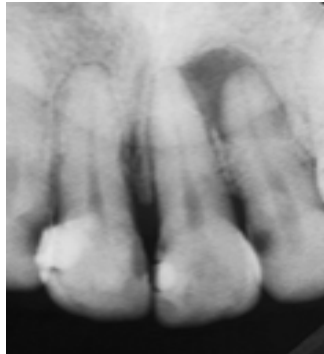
Radiographic examination showed periapical lesion on tooth 21 and 22.
